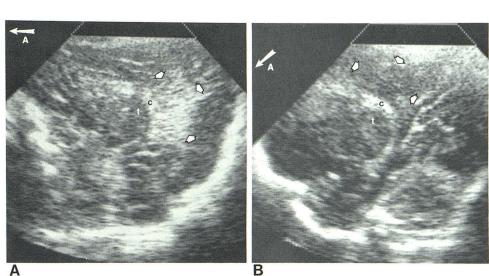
Parasagittal sonogram (5.0 MHz) through anterior (A) and posterior (B) fontanelles. Normal, fine, hyperechoic, peritrigonal blush (*arrows*) is seen through anterior but not posterior fontanelle, although that area is well demonstrated (*arrows*). A = anterior; c = choroid plexus; t = thalamus.
